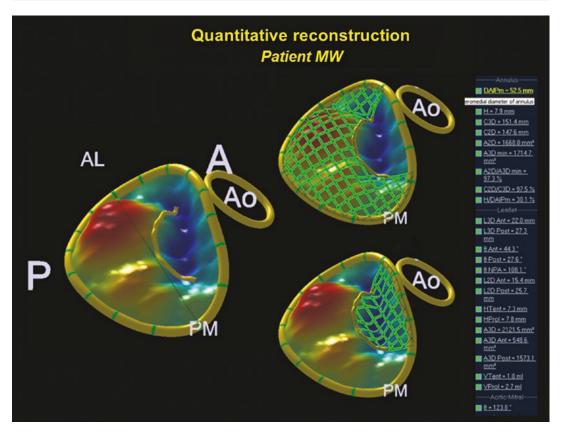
Quantitative measures may be applied to mitral valve closure by three-dimensional echocardiography. Left panel shows computerized contouring of leaflet surfaces of the three-dimensional echocardiogram from the same patient as in Figs. 10.93 and 10.94 (left panel) in the same
